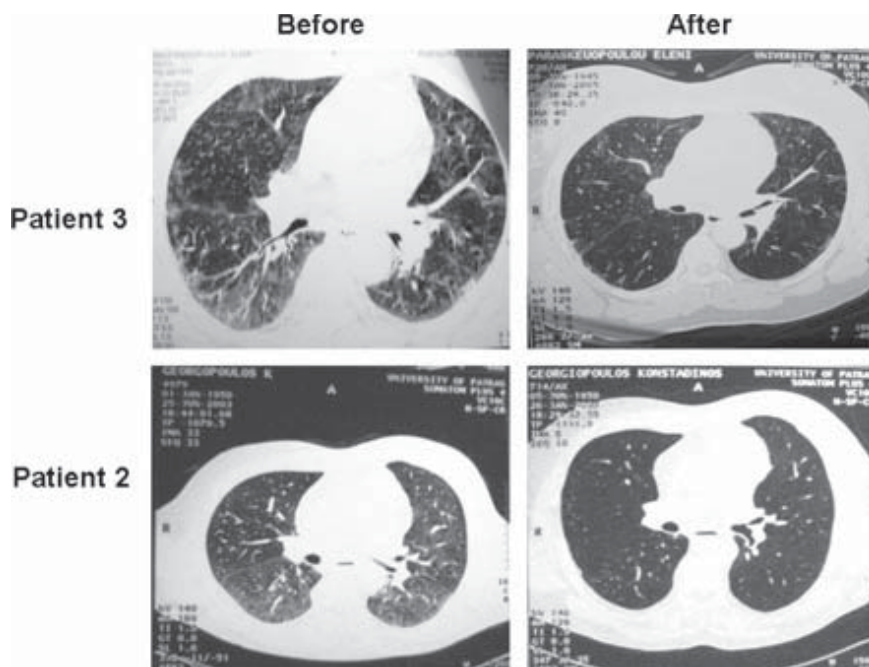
High-resolution computed tomography scan showing appearance of the lung before and after treatment with mycophenolate mofetil. Source: Liossis *et al.* (2006).
